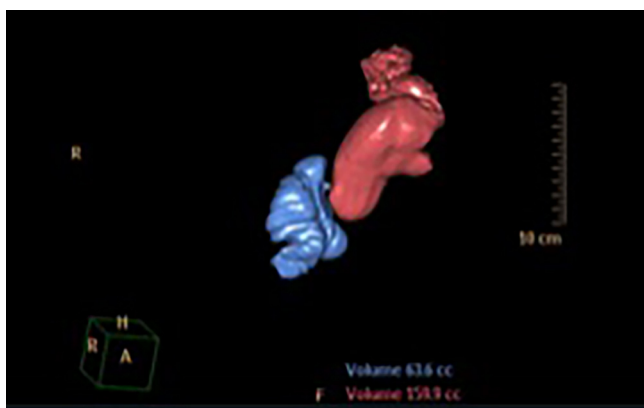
CT Pouchography.
